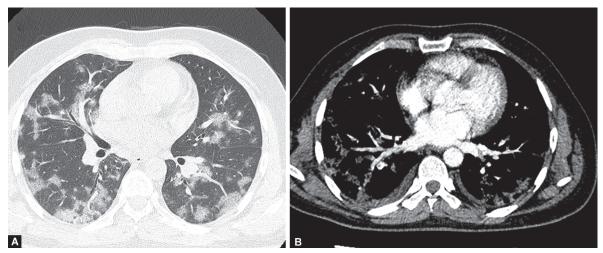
Images of a 42-year-old woman with COVID-19 pneumonia: (A) Axial unenhanced chest CT at the day of admission showing bilateral multilobar peripheral and peribronchovascular ground glass and consolidative opacities; (B) Axial pulmonary CT angiography confirming bilateral filling defects in segmental and subsegmental branches of the pulmonary artery
